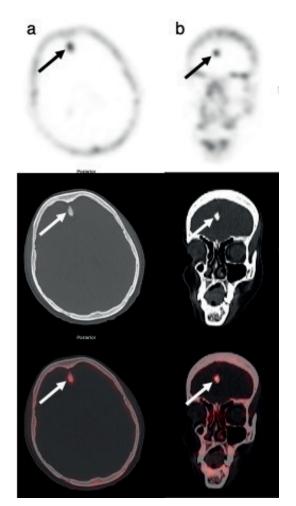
¹⁸F-sodium fluoride (¹⁸F-NaF) positron emission tomography/computed tomography (PET/CT) scan of a 45-year-old female with right-sided breast cancer. Axial (a) and coronal (b) images of her scan are shown. There is a focus of uptake of ¹⁸F-NaF in the midline calvarium on the PET scan (upper row). This corresponds to the ossification seen in the midline on the CT scan (middle row) and on co-registered PET/CT images (lower row), which suggests that this is an incidental ossification of the falx cerebri rather than a pathological lesion.
